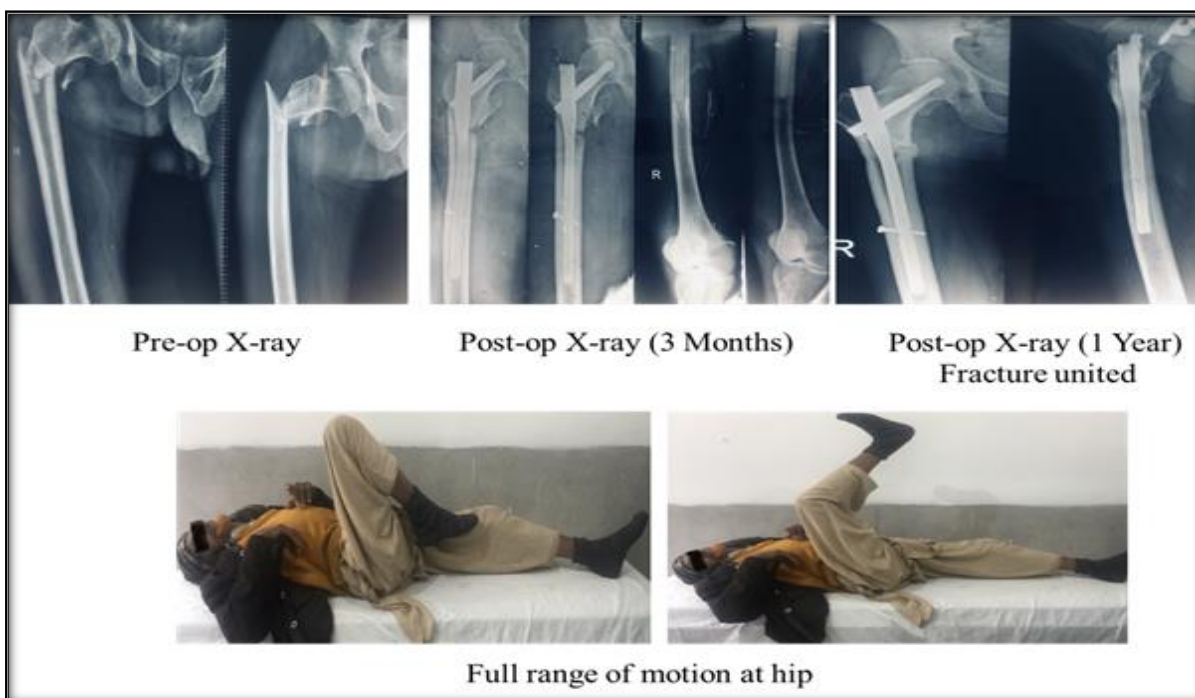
Case details-pre and post-op Xray showing fixation with PFNA, Range of motion at hip joint post-operative at 1 year.
